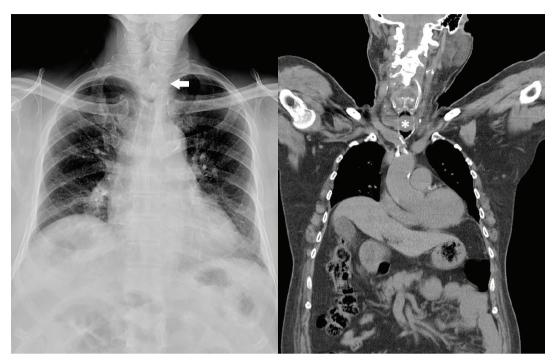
Chest radiograph(arrow) and computed tomography of the chest(asterisk) showing a mass lesion at the upper trachea.
